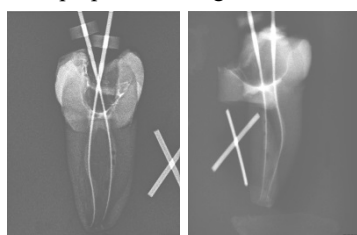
Determination of canal curvature according to Luiten (Luiten et al., 1995) (left), Measuring the curvature in the radiograph bucco-lingual (middle) and mesio-distal view (right) with the metal cross as guideline for accuracy in superimposition.
